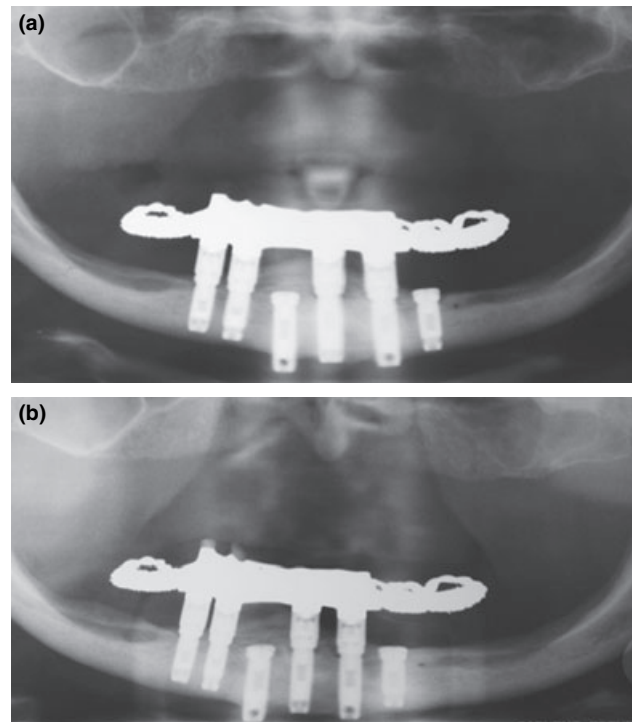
Patient 1. (a) Postoperative panoramic radiograph on 62-year-old female patient, immediately loaded prosthesis on 4 implants. (b) Postoperative panoramic radiograph at 15-year follow-up. Notice little discernable difference of marginal bone height and some evidence of remodeling of the body of the mandible.
